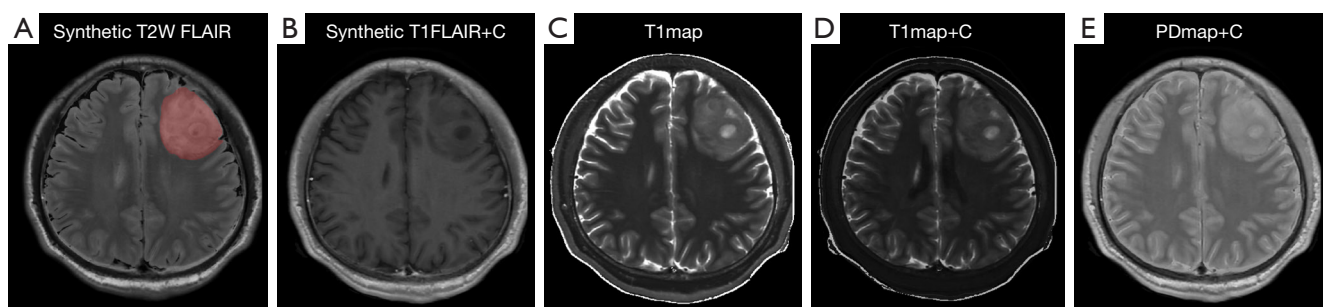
Representative images from a 28-year-old male patient with isocitrate dehydrogenase mutant astrocytoma. The red mask on the synthetic T2W FLAIR image (A) shows the lesion included in the volume of interest. Synthetic T2W FLAIR images enable visualization of tumor-associated edema, while synthetic T1FLAIR+C images facilitate observation of tumor enhancement and cystic. Radiological features: tumor location (frontal lobe), tumor size (49.33 mm), tumor border (sharp), enhancement style (no), enhancement degree (no), edema degree (0), hemorrhage (no), cystic and necrosis ($\leq 25\%$), signal characteristics (heterogeneous), cross midline growth (no). (B-E) synthetic T1FLAIR image, T1map, T1map+C, and PDmap+C at the same level as figure (A). T2W FLAIR, T2-weighted fluid-attenuated inversion-recovery; T1FLAIR+C, post-contrast T1 fluid-attenuated inversion-recovery; T1map+C, post-contrast T1map; PDmap+C, post-contrast PDmap.
